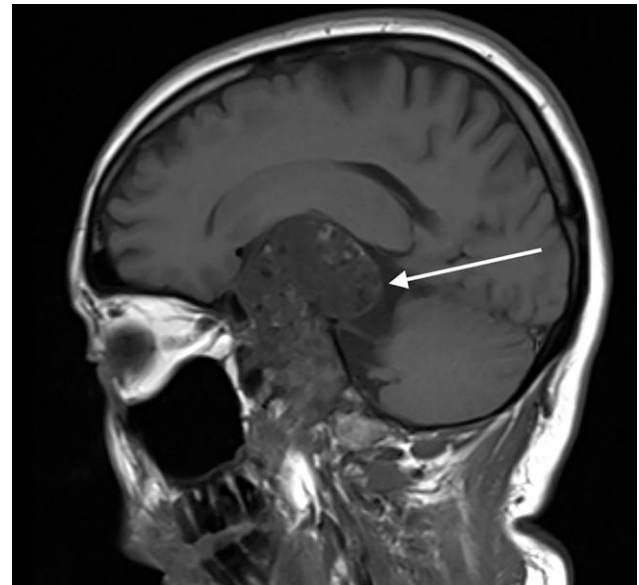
Magnetic resonance imaging of the brain (T1-weighted sagittal view) demonstrating the large skull base mass as described in Fig. 1. The mass appears to destroy the sella turcica and extends into the suprasellar area.
